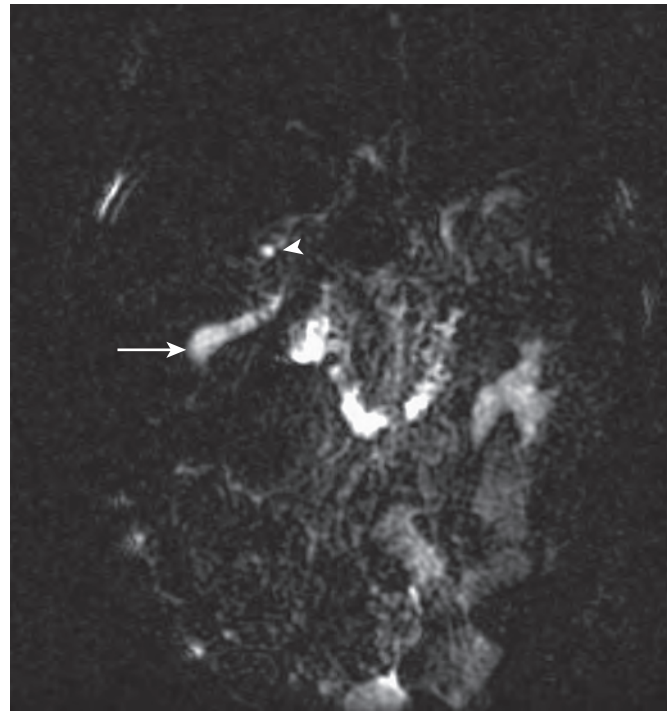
Biliary atresia: MRCP findings. Coronal, thick-slab, T2-weighted image of a 19-day-old infant with cholestasis shows a small focus of increased signal intensity (arrowhead) in the porta hepatis that represents a cystic lesion within the porta hepatis. A gallbladder is identified (arrow), but no linear or branching structures suggesting bile ducts are identified. Lack of identification of the right, left, and main hepatic ducts and common bile duct is consistent with biliary atresia. (Courtesy Myung-Joon Kim, MD, Yonsei University College of Medicine, Severance Hospital, Seoul, Korea.)
